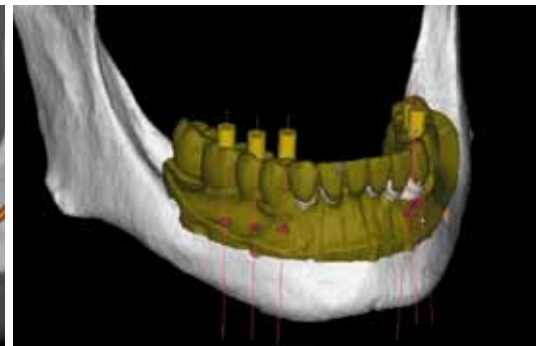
The CT data are matched with the scan model in the software.
